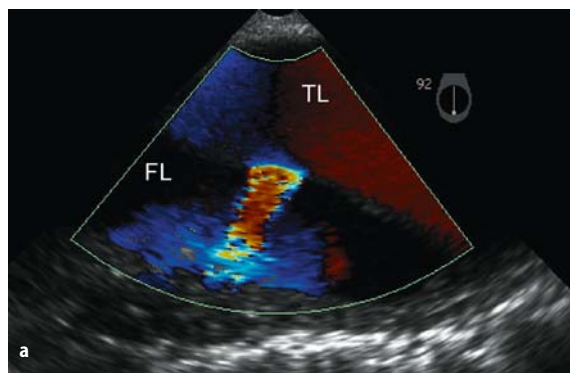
Dissection of the descending aorta. a Color flow through the intimal tear, from the true lumen (TL) towards the false lumen (FL). b Pulsed Doppler image through the intimal tear
